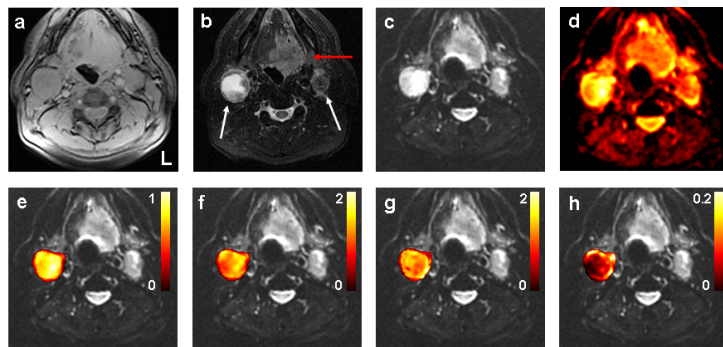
Axial MRI images from the oral cavity of patient 9. (a) PD image, (b) T2 STIR image, (c) realigned mean b=0 image, (d) ADC<sub>mono</sub> map. The white arrows in (b) indicate the primary tumor and metastatic nodes, respectively. Figures (e-f) display pixel-by-pixel calculation outcomes for the right node. (e) ADC<sub>mono</sub> (10<sup>-3</sup> mm<sup>2</sup>/s), (f) D<sub>app</sub> (10<sup>-3</sup> mm<sup>2</sup>/s), (g) K<sub>app</sub>, and (h) chi<sup>2</sup>.
